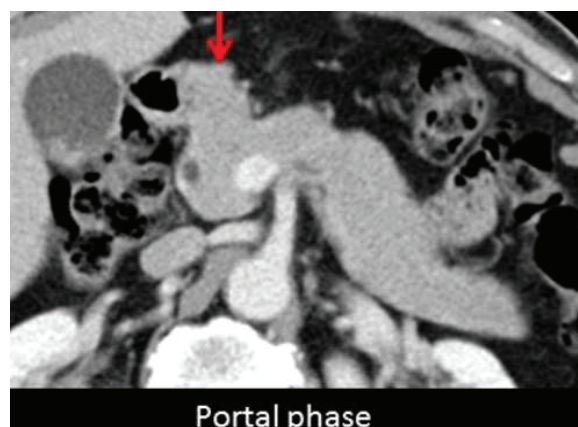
CT images - Normal version of the contour of the pancreatic head
